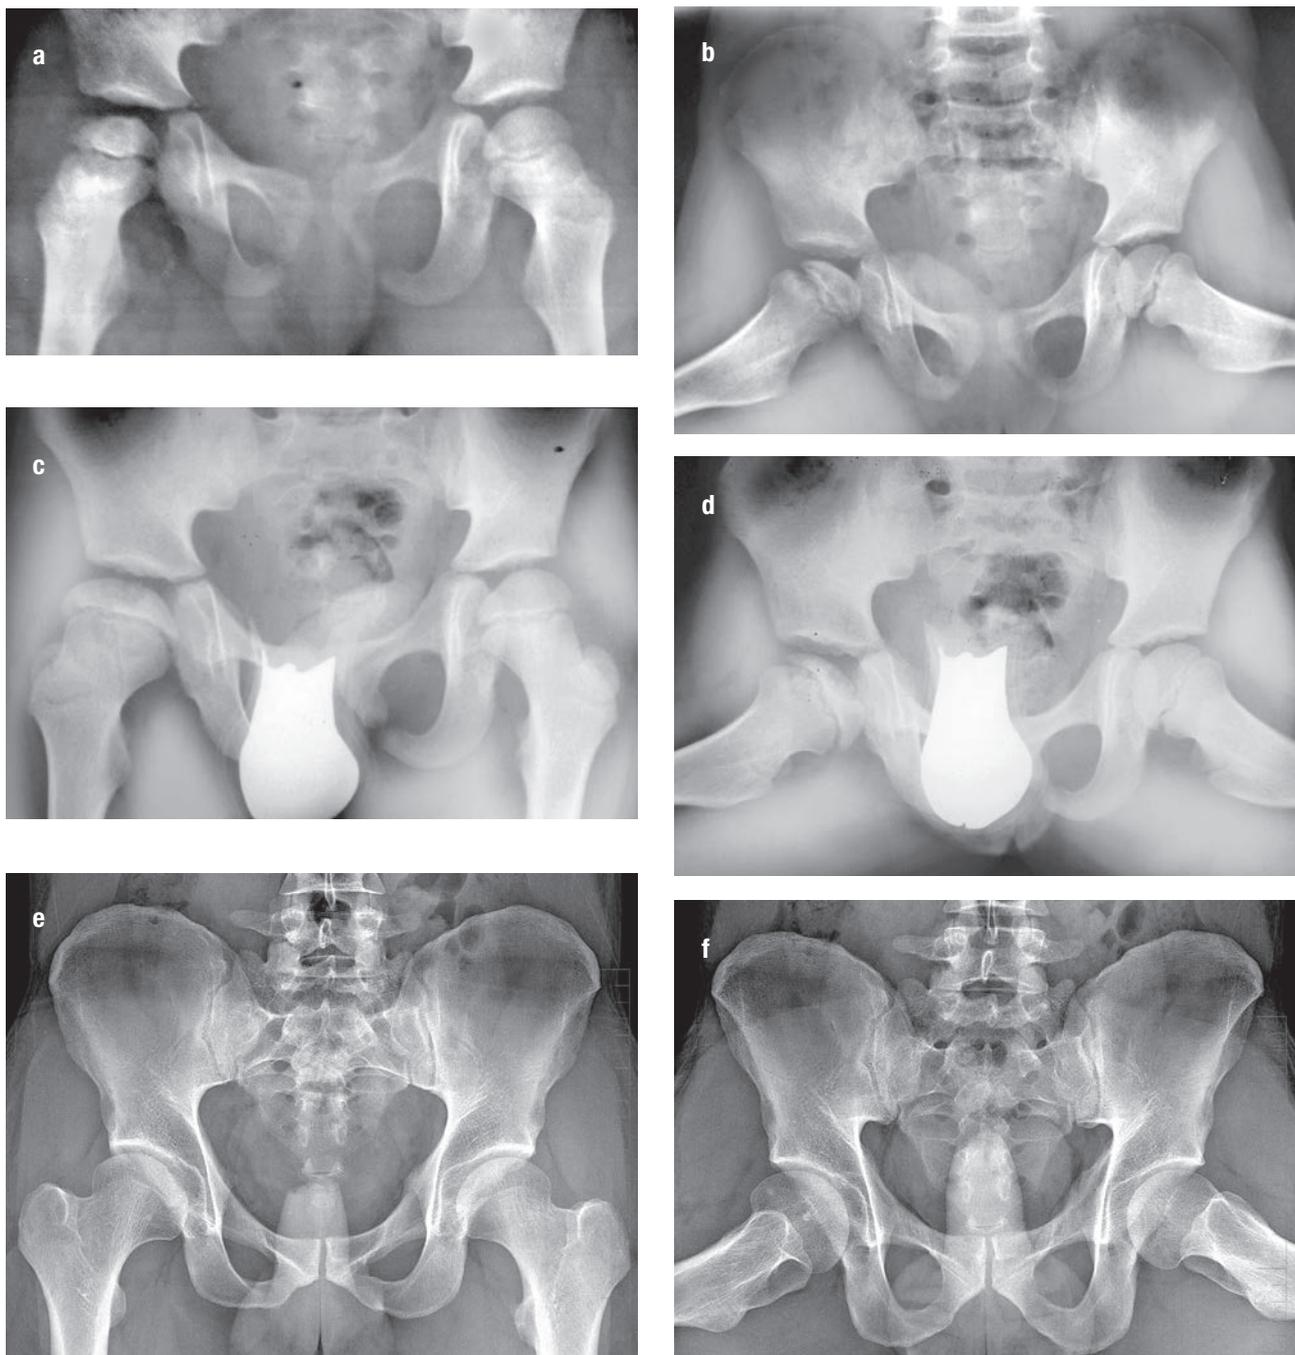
X-ray documentation of twin B, in whom the disease began at the age of 6 years and 4 months: a, b – anteroposterior and Lauenstein pelvic views at the beginning of a therapy of the right proximal femoral epiphysis; c, d – follow-up images 12 months later; e, f – follow-up images 23 years after treatment, showing a slightly oval right femoral head and complete sacralization of L5.
